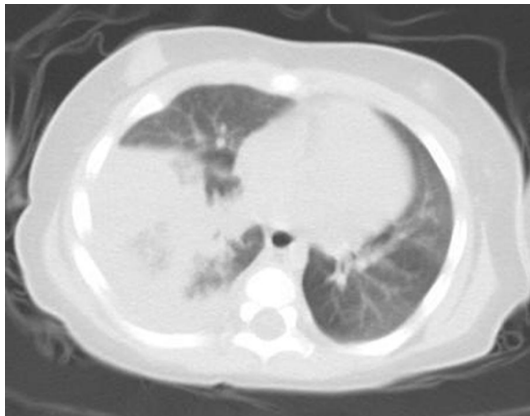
CT scan revealing high density shadows in the right lung when the infant was admitted.
